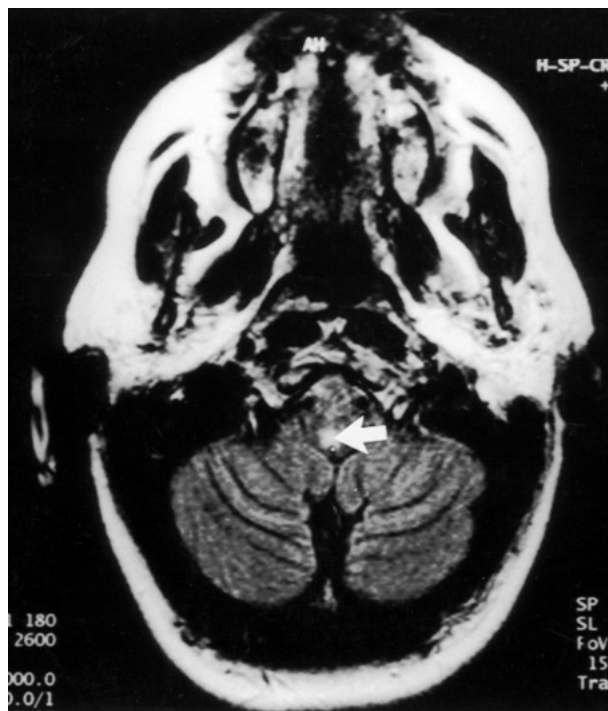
Magnetic resonance axial image (T1-weighted, gadolinium-enhanced) of the lower brainstem of the case patient demonstrating a small, enhanced region (arrow) involving the dorsomedial medulla.
